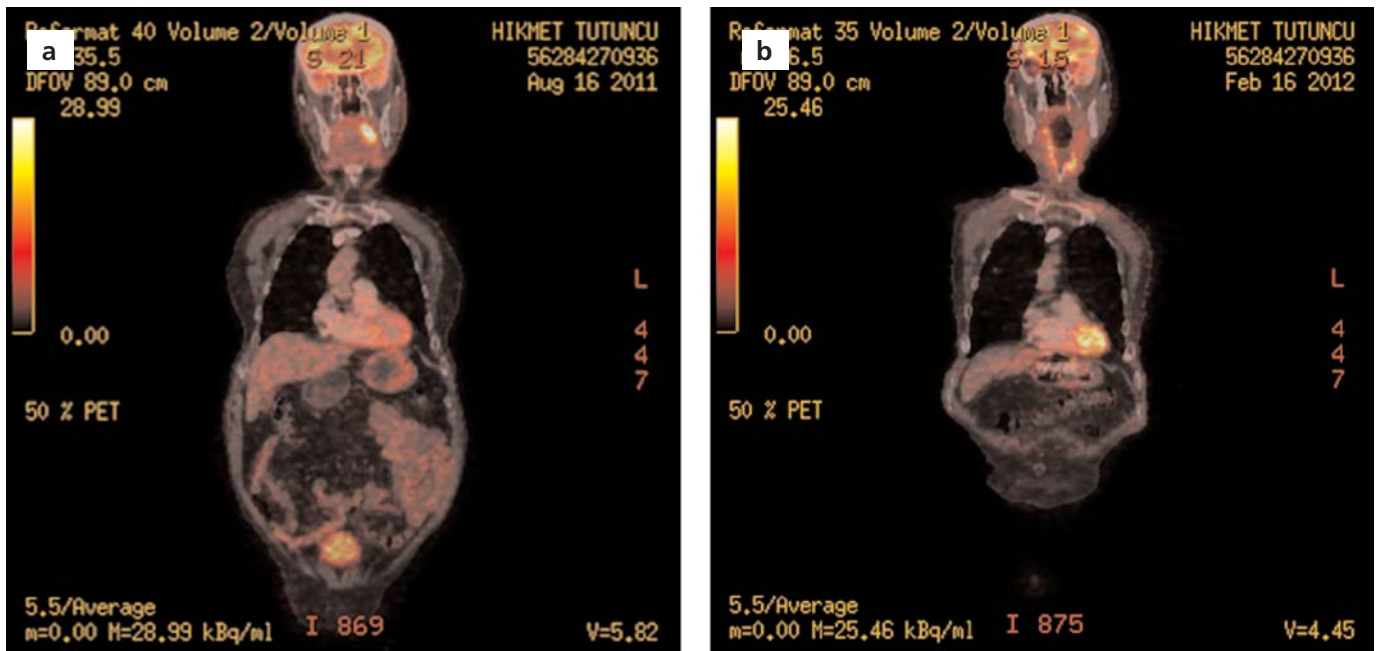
Preoperative PET/CT demonstrated the mass at the base of the tongue with a hypermetabolic tumoral bulky lesion (SUV:14) and a lymphadenopathy (7 mm in size) at the left neck with a slight increase in SUV (a). Postoperative 5th month PET/CT: hyper metabolic nodules, that were considered in the favor of lung metastasis, were observed in both lungs when compared with the previous PET/CT, although no sign of disease was seen at the base of tongue and neck.
